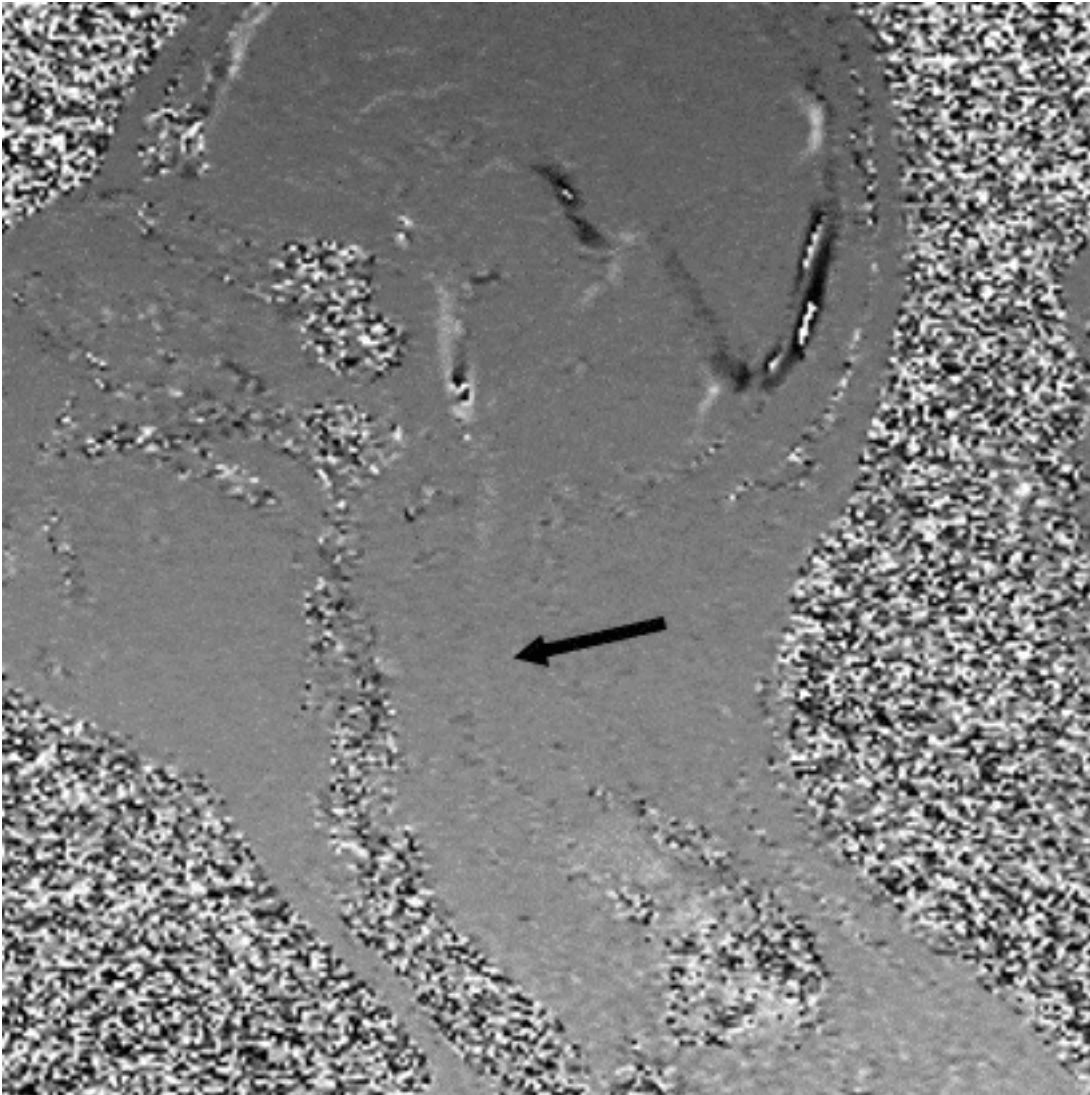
Animated MRI scans show CSF fluid along the spine, indicated by the pulsing dark (Source: <https://www.regenexx.com/craniosacral-therapy-research/>)
